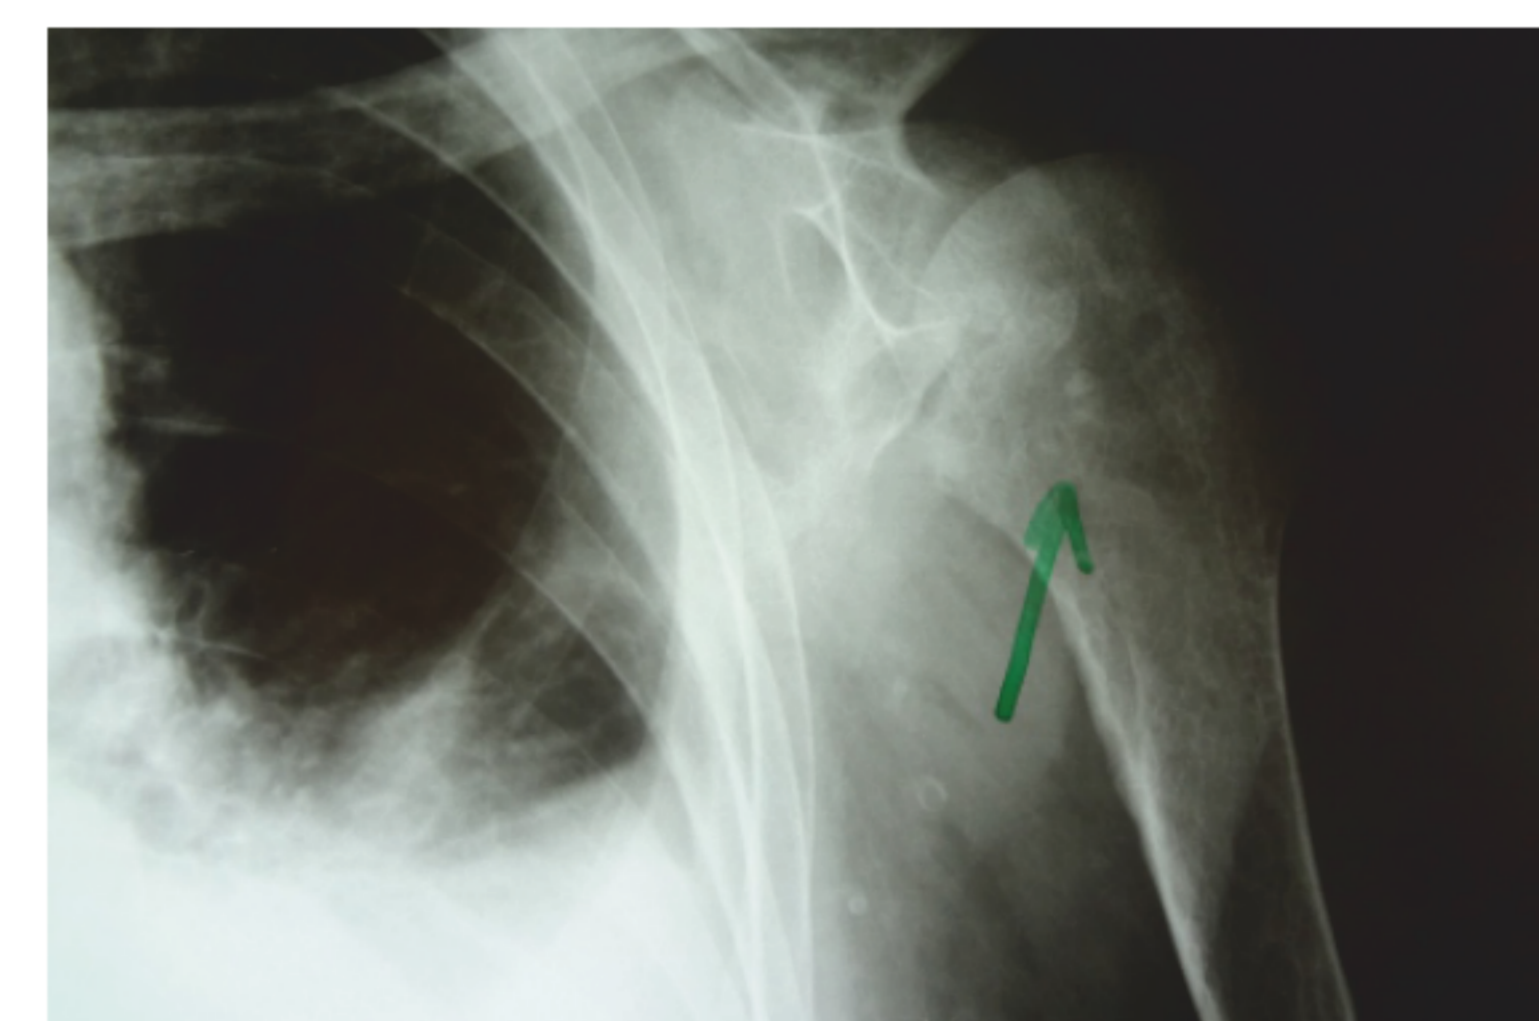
X-ray image of metastatic calcification
